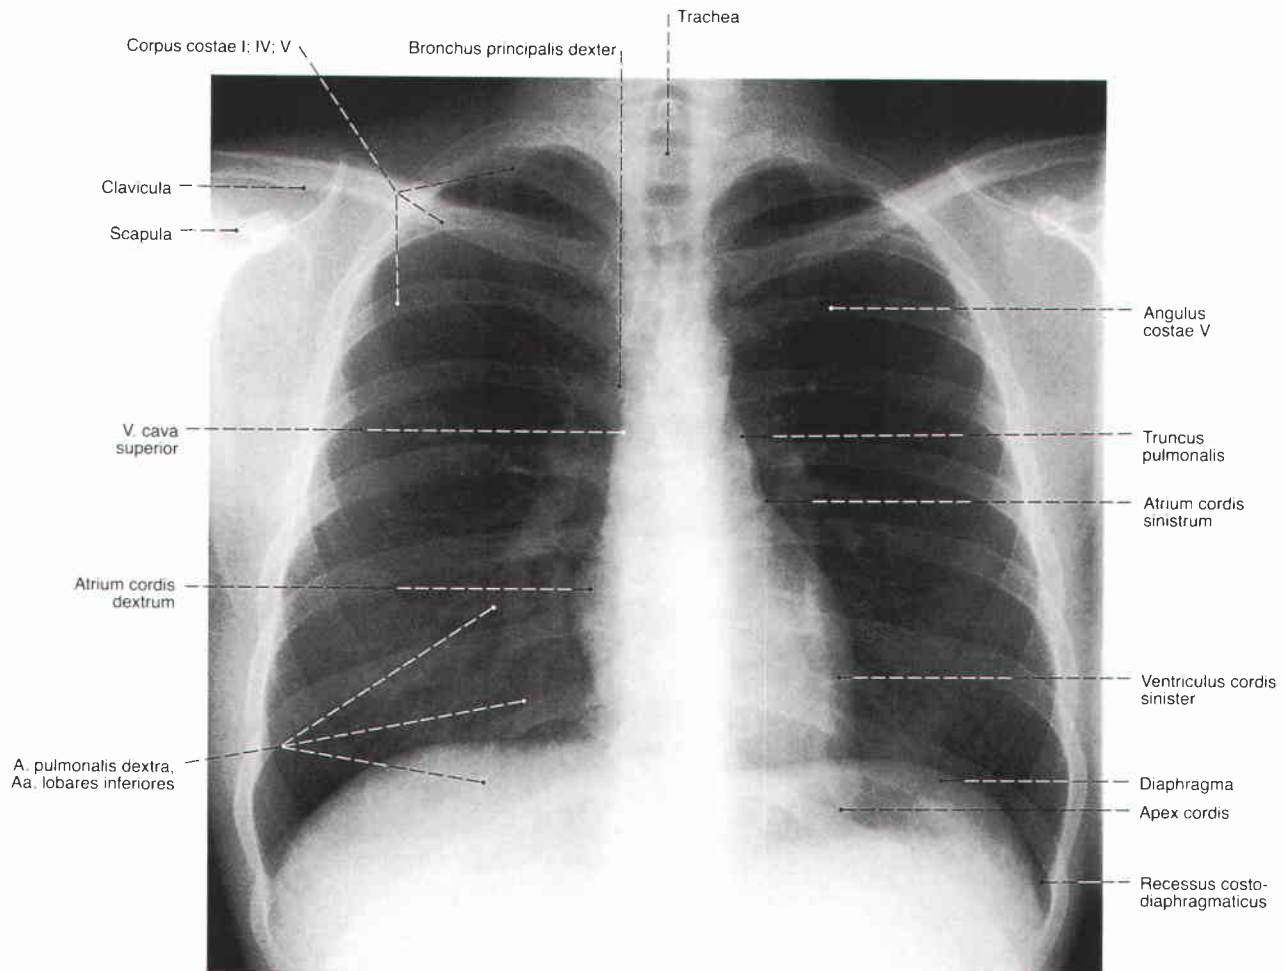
Thorax, Cavea thoracis, and thoracic viscera; PA-radiograph of a 27-year-old man; the beam is directed sagittally onto the middle of the sternum.
